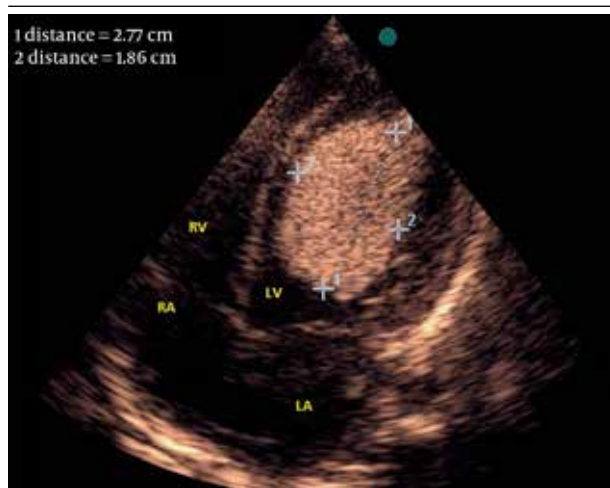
Transthoracic echocardiography of the child at two months old, showing a left ventricular tumor
